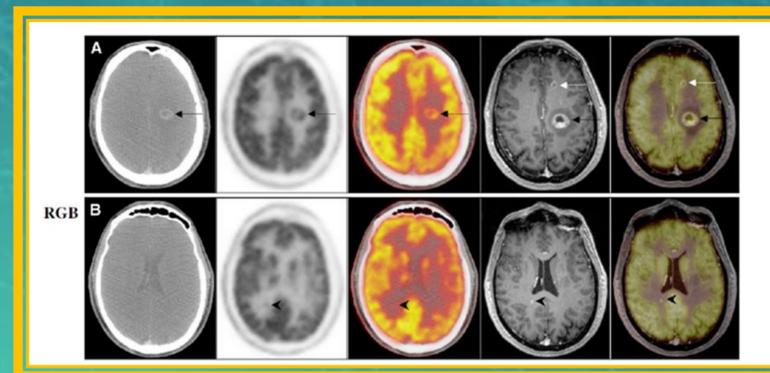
F-FDG Uptake in PET MRI and CT Images.³
